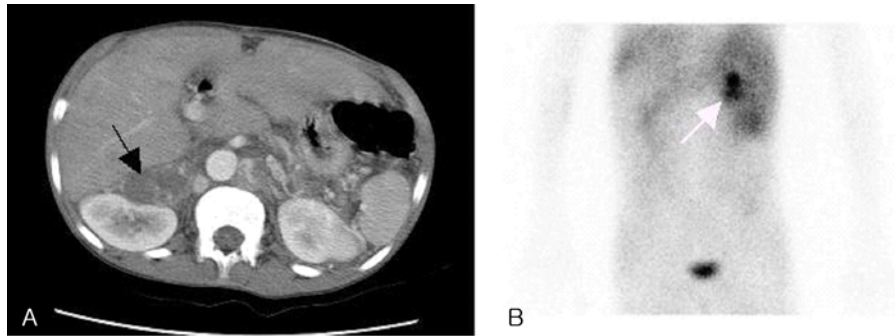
A) Abdominal CT of patient 2. There was a multiseptate cystic lesion with peripheral-wall enhancement in the anterior aspect of the right kidney (filled arrow). B) An MIBG scan of patient 2 (posterior view) showed abnormal MIBG accumulation adjacent to the right kidney (open arrow).
